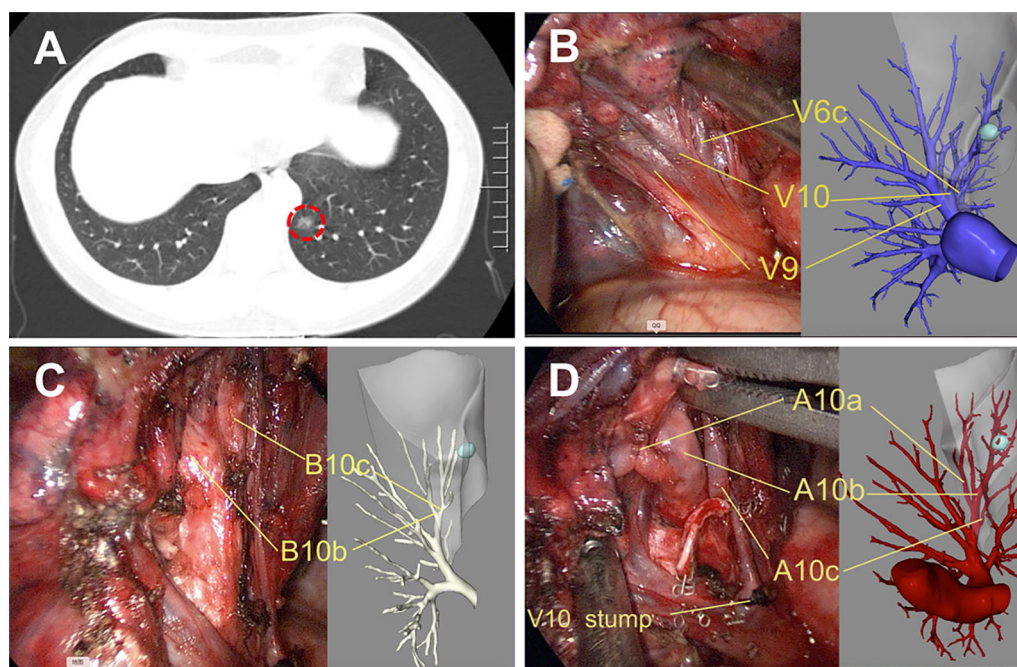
Precise left S¹⁰ segmentectomy according to the real-time 3D reconstruction guidance. (A) CT scan showed a GGOs lesion in the left S¹⁰; Branches pulmonary vein (B), bronchus (C), and pulmonary artery (D) of the target segment were confirmed by real-time guidance of 3D reconstruction. 3D, three-dimensional.
